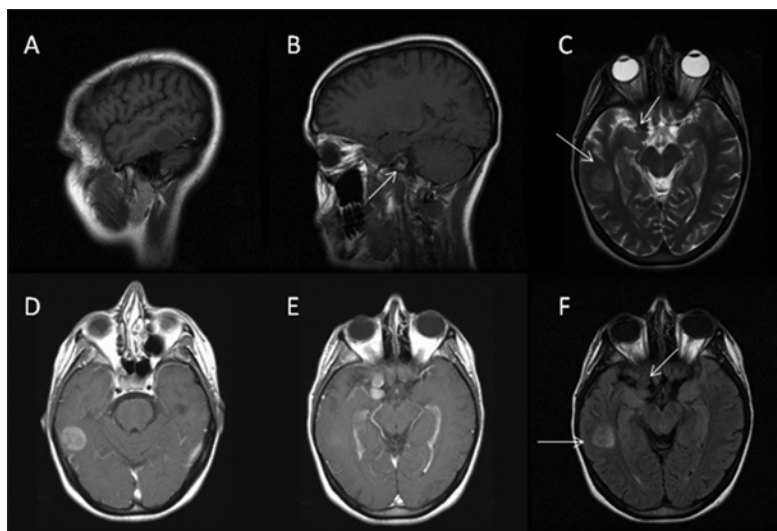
MRI Characteristics of Patient's Meningeal Melanocytomas.
